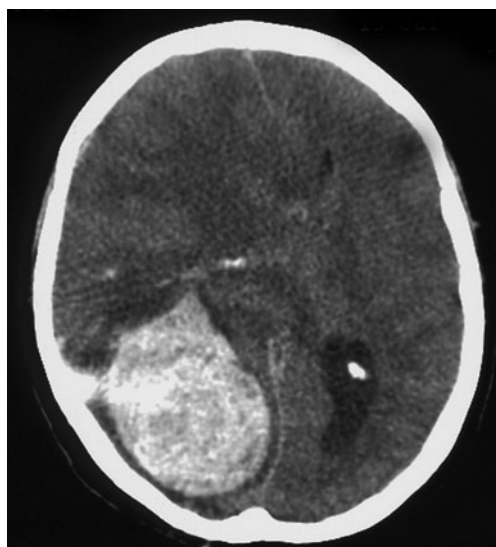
Computed tomography realised in emergency 4 days post-embolisation, showing an important occipital haemorrhagic mass, occipital oedema and also midline shift with subfalcorial herniation
